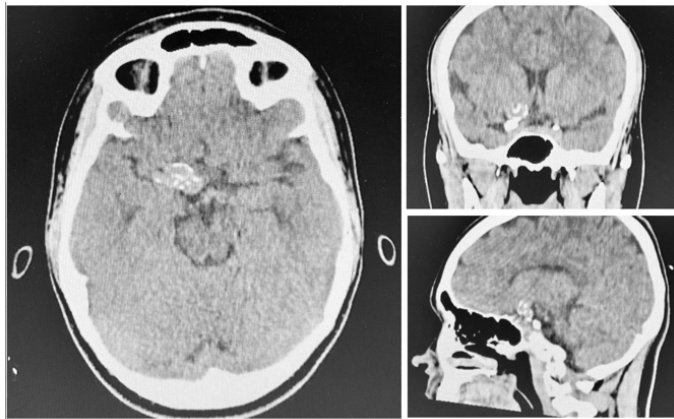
Axial, coronal and sagittal CT scans showing focal calcification in right M1 arterial wall.
